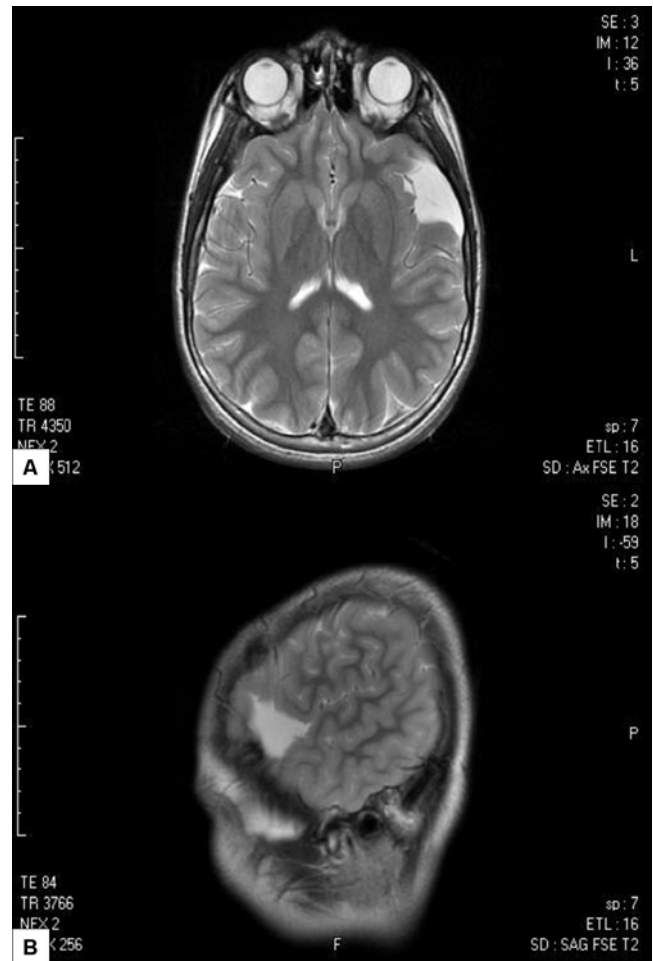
Axial (A) and Sagittal (B) brain MRI images showing the arachnoid cyst in the left frontotemporal convexity area.
